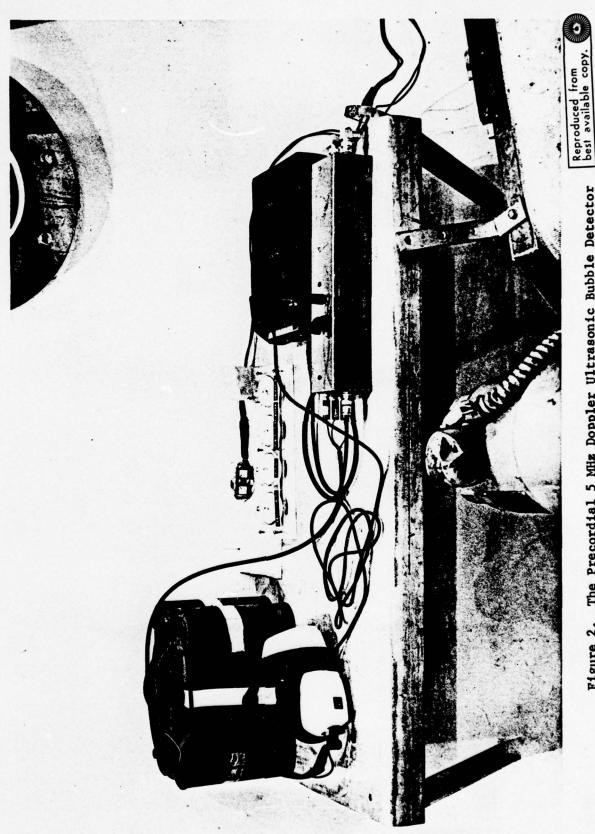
The Precordial 5 MHz Doppler Ultrasonic Bubble Detector
